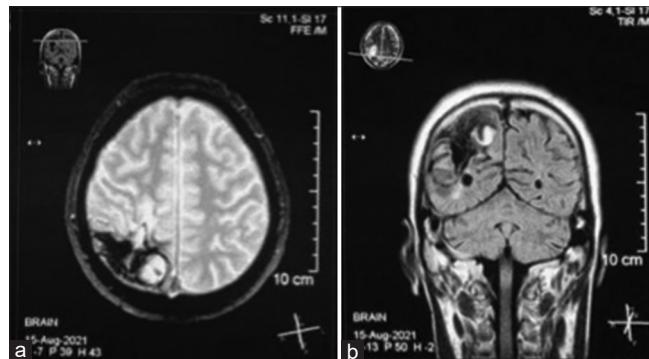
(a) Axial T2 magnetic resonance imaging (MRI) weighted image demonstrated a linear and round flow void features of a vascular lesion and an area of parenchymal hypointensity indicating a previous hemorrhage. (b) Sagittal view flair MRI demarcates a cavity and hemosiderin accumulation.
